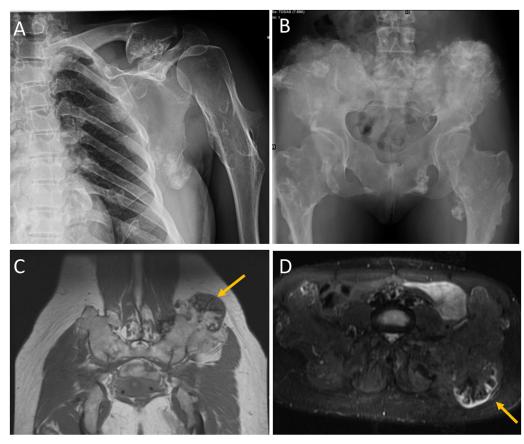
A. 24-year-old female with multiple osteochondromatosis diagnosed in childhood. Plain radiograph (A, B) show multiple pedunculated and sessile exostoses with chondral calcifications in both axial and peripheral skeleton with no signs of complication. The largest one emanates from the left iliac bone with low signal in T1WI (arrow in C) and has a 7 mm width cartlage cap visible in STIR sequence (arrow in D) with smooth edges. (Color version of figure is available online.)
